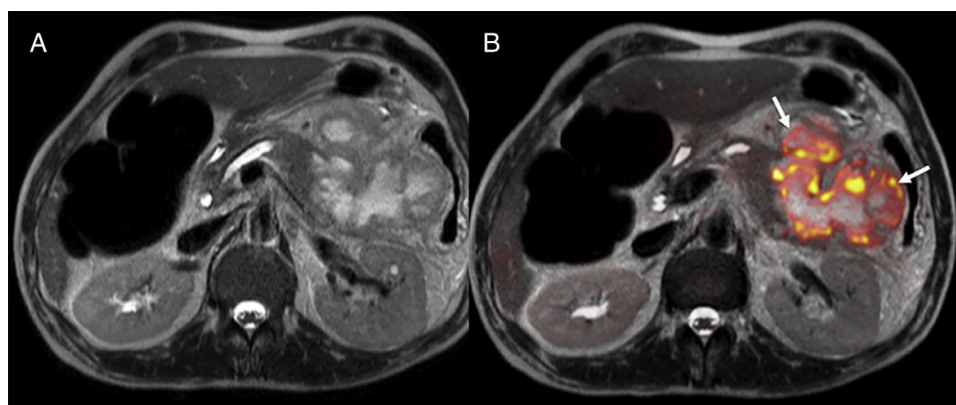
45-year-old patient with necrotizing acute pancreatitis and presence of encapsulated pancreatic and peripancreatic necrosis with signs of infection on the MRI. Axial T2-weighted image (A), diffusion weighted imaging (DWI) in T2 and diffusion imaging with high b values ($b800$) in the color-coded map (B). The fusion of the images shows the restriction of diffusion in the periphery of the collection suggestive of its overinfection (arrows).
